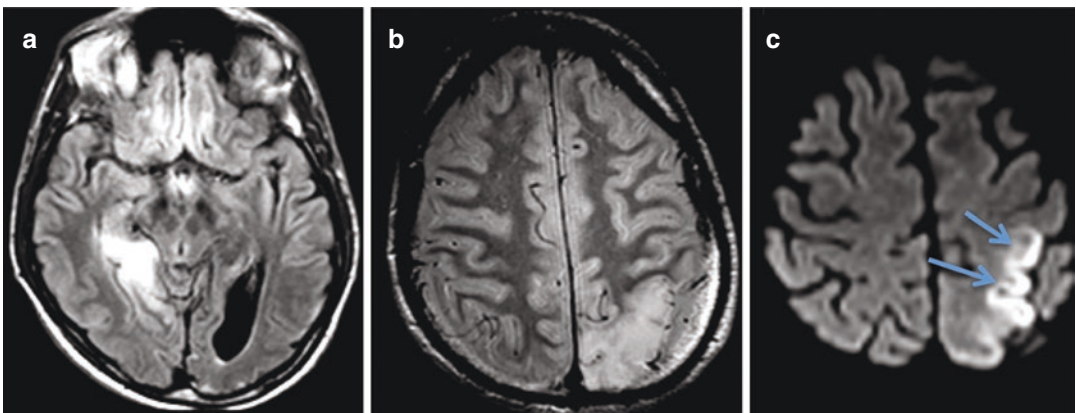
MELAS in a 42-year-old man with multiple stroke-like episodes and epileptic seizures. MRI shows an older right occipital infarct (a) and a subacute left parietal
